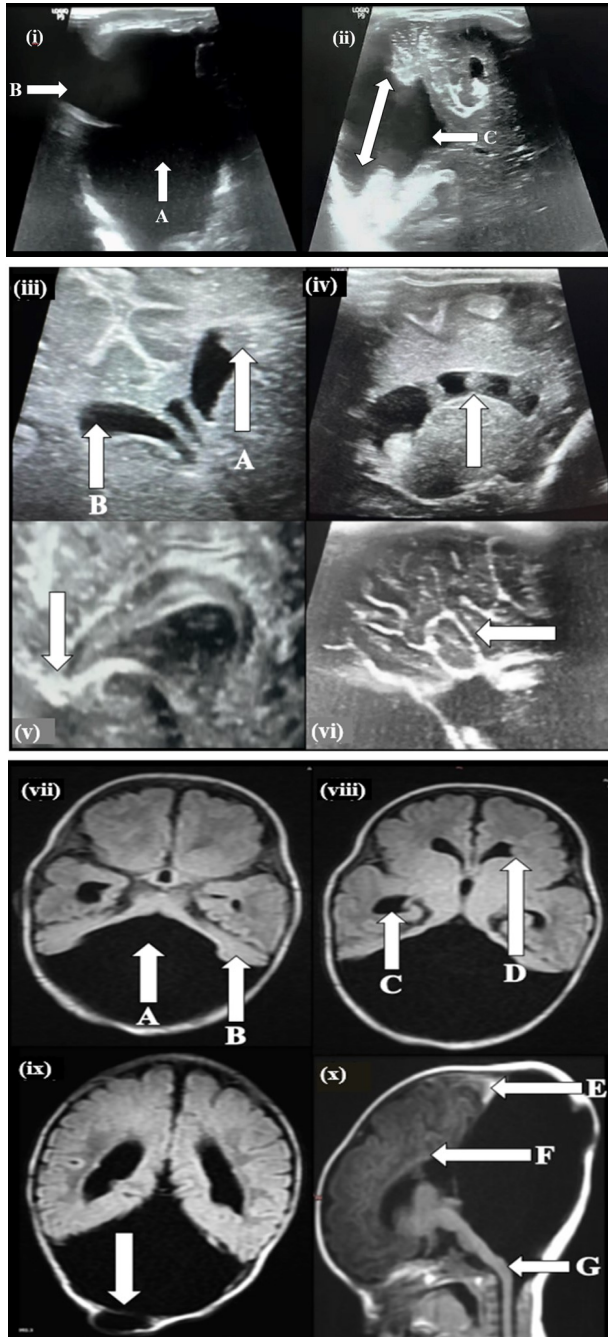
Ultrasonographic and magnetic resonance images of brain
